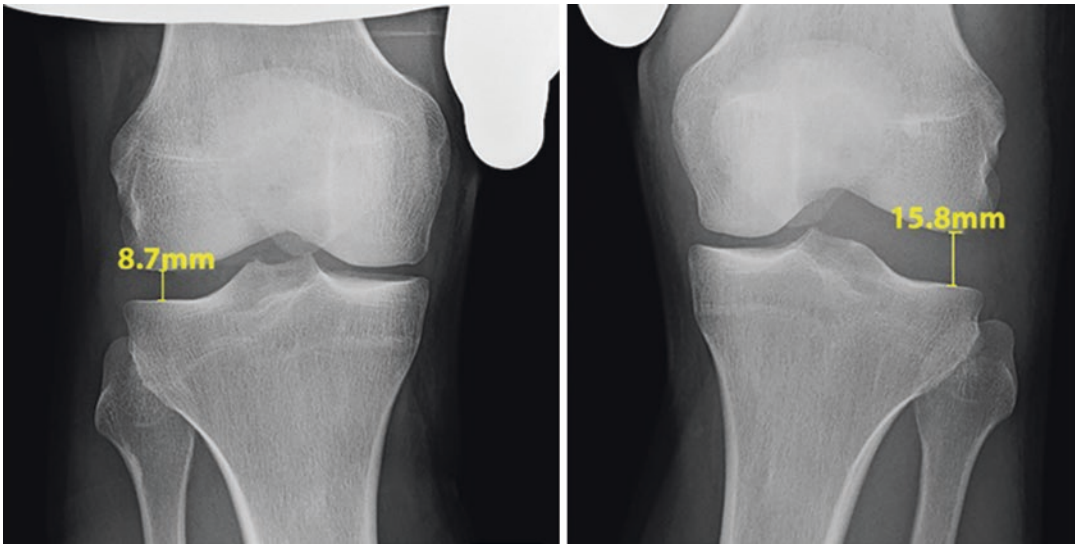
Varus stress radiographs to evaluate the integrity of the posterolateral corner preoperatively. In this picture there is a 7.1 mm side-to-side difference consistent with a complete posterolateral corner (PLC) injury
